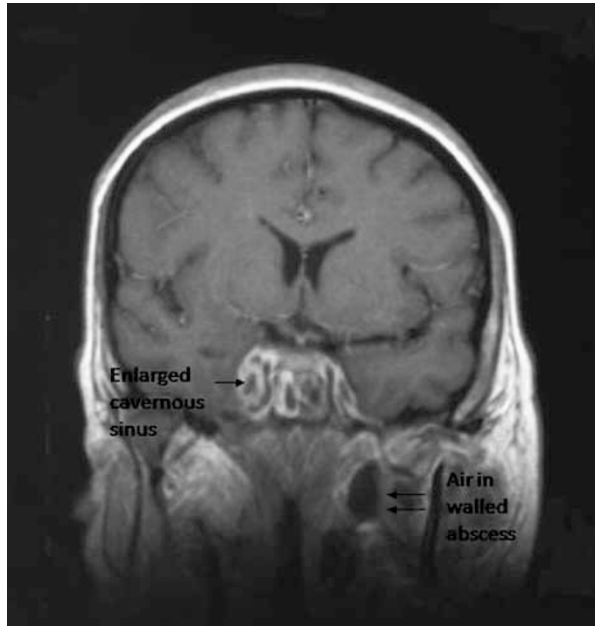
Coronal MRI (T1, post-gadolinium) image showing enlarged right cavernous sinus and left parapharyngeal abscess.
